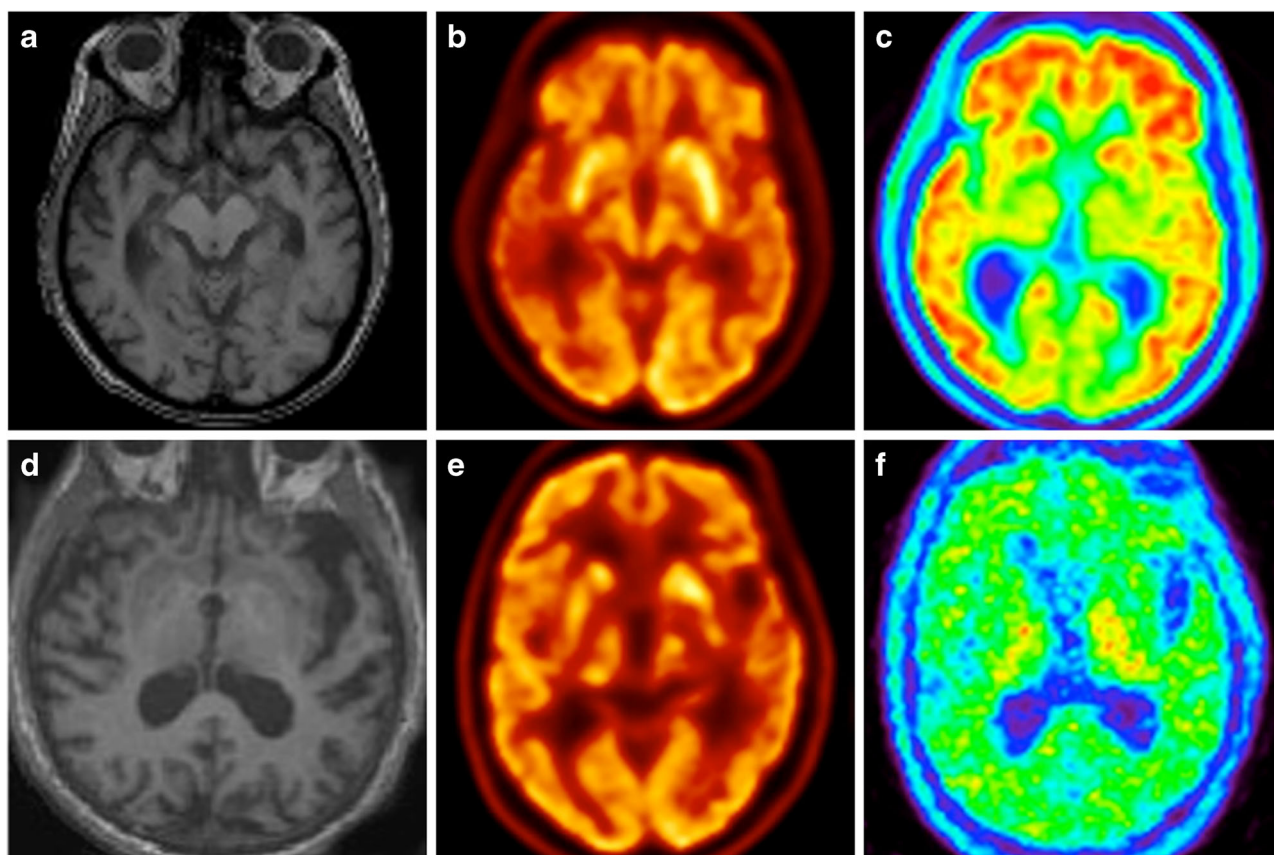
Patient with AD (top row) shows atrophy in medial temporal lobe and hippocampi in MRI (a), hypometabolism in temporal lobes in FDG-PET (b), and widespread cortical amyloid deposition in frontal, parietal, and temporal lobes in amyloid PET (c). Patient with nfvPPA (bottom row) demonstrates atrophy in lateral and anterior temporal lobes and frontal operculum on the left side in MRI (d), hypometabolism in left peri-insular region in FDG PET (e) with no evidence of amyloid deposition (f).
